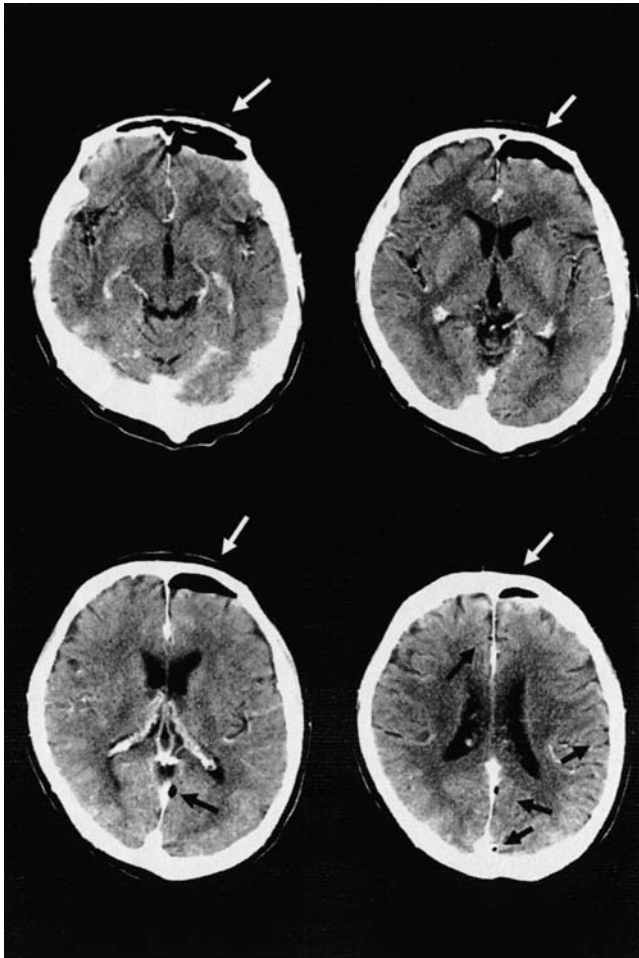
Head computed tomography (CT) scan on day 14 after the second catheter insertion. About 15 ml of air in the frontal subdural region (*white arrows*), backward compression of the brain, and some air bubbles in the interhemisphere fissure (*black arrows*) were detected
